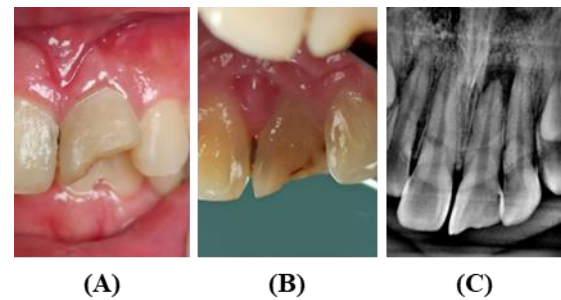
Objective Examination, Labial (A), Palatal (B), Radiographic Examination (C)
